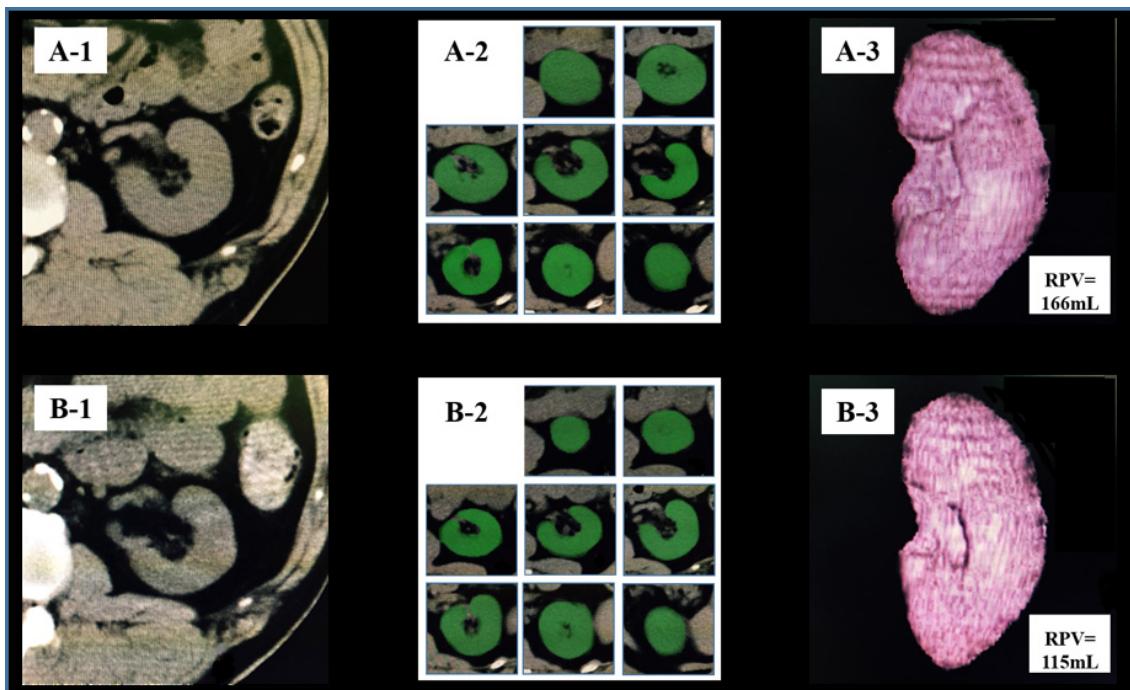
Non-contrast computed tomography (CT) images on the workstation showing the measurement of the left renal parenchymal volume (RPV)
